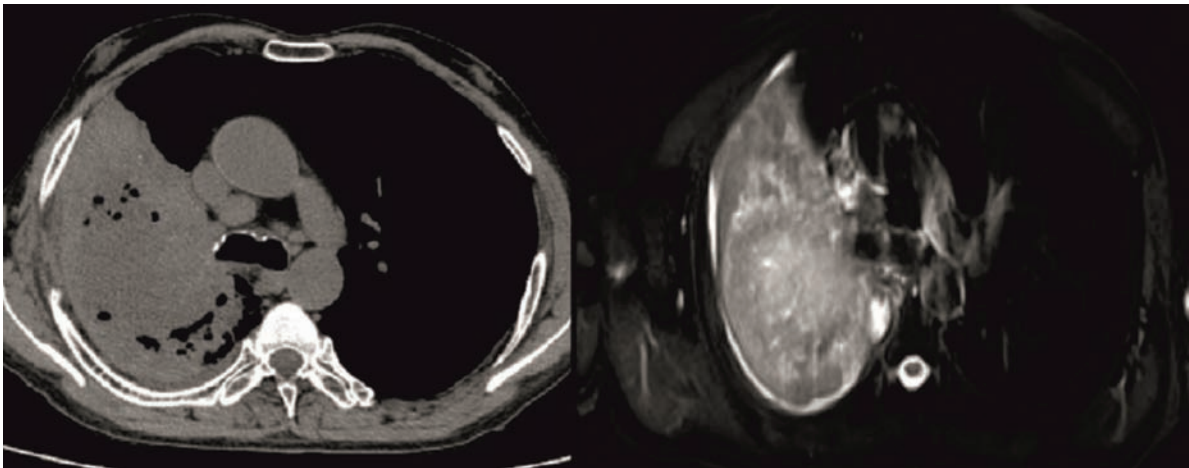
Axial NECT image (mediastinal window) (left) & axial fat-suppressed T2W MRI image (right) showing central tumor with surrounding consolidation
